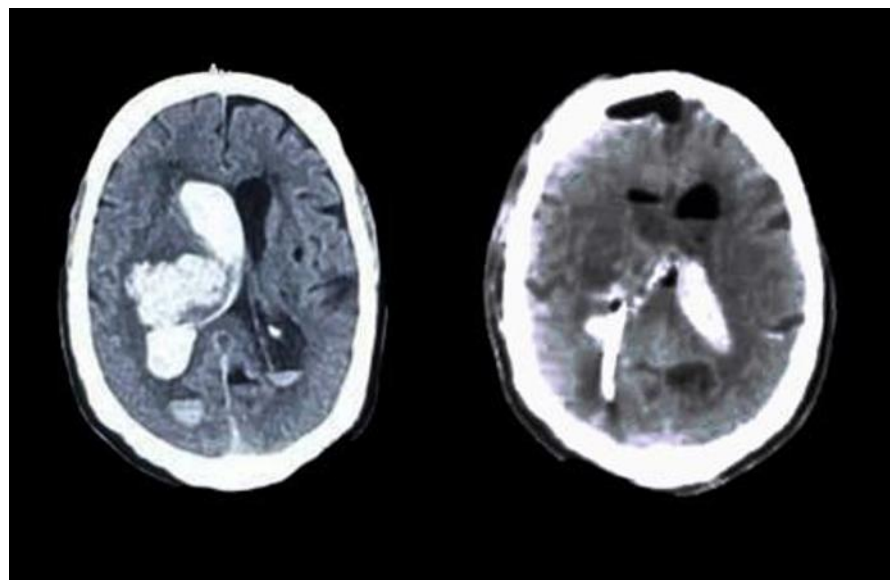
(left) Preoperative CT Brain showing a dense right gangliocapsular bleed with intraventricular haemorrhage. (right) Postoperative CT Brain showing a near total evacuation of the previously seen right Gangliocapsular bleed, with a ventricular drain in the right lateral ventricle.
